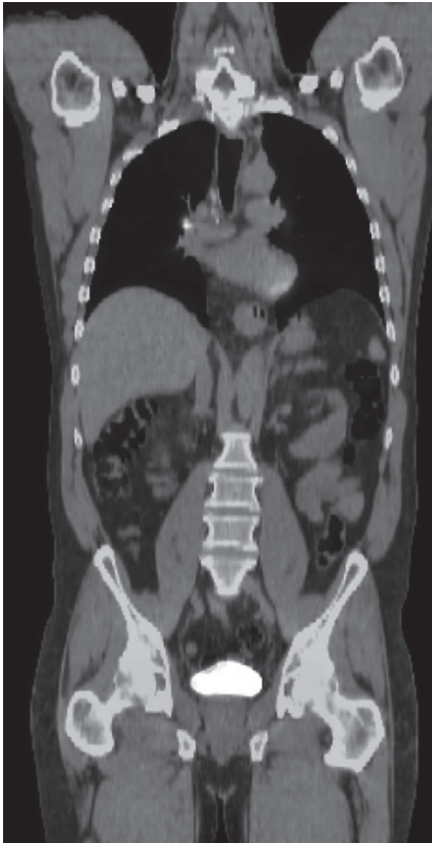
Coronal view of the positron emission tomography (PET) scan revealed fluorodeoxyglucose (FDG) avid right hilar and paratracheal lymph nodes. The endobronchial lesion was not present on the PET-CT scan.
